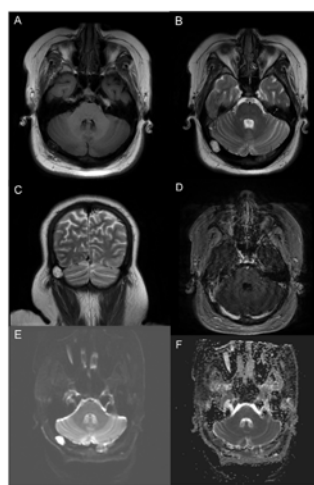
Subsequent contrast enhanced MRI of the brain reveals a 1.6 x 1.0 cm low T1, high T2 (A, B & C) nonenhancing (D), intensely diffusion restricting (E, F) lesion within the right parietal calvarium. This markedly thins the inner and outer tables (B, C) and narrows the right transverse sinus (D). This appearance is consistent with an intradiploic epidermoid inclusion cyst.
